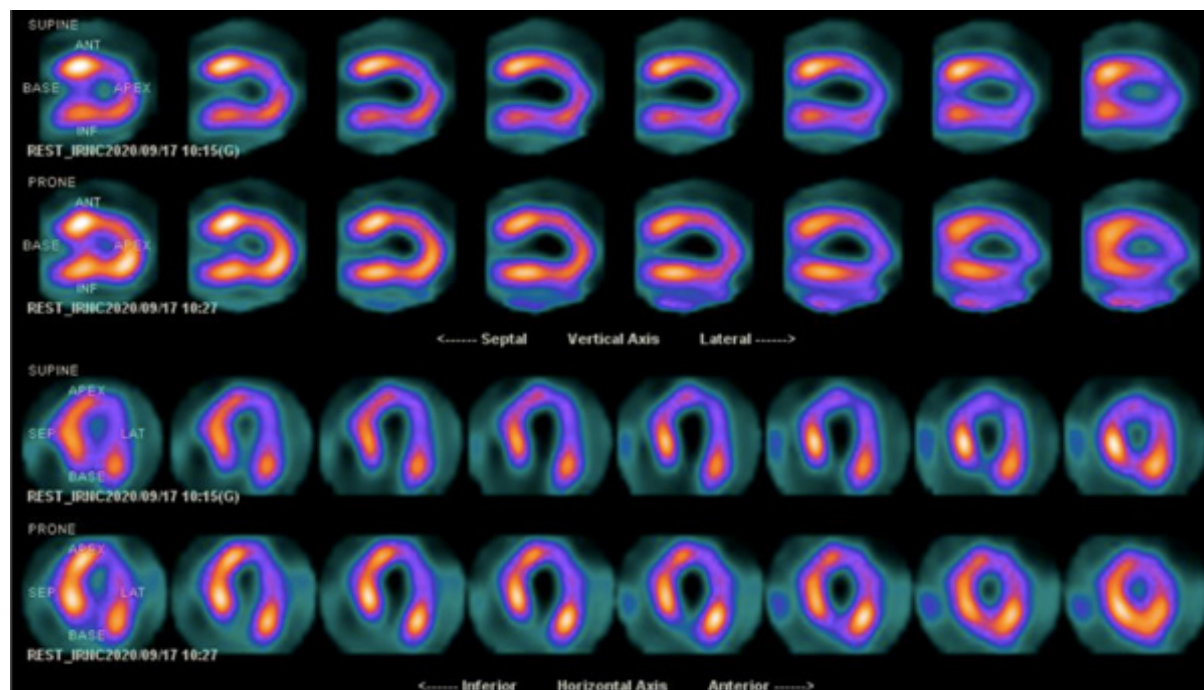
Myocardial scintigraphy with sestamibi-99mTc at rest. It shows an abnormal distribution in myocardial perfusion, with moderate reduction in the apex and mid-apical segments of the lateral wall, with a slight inferolateral extension, affecting 20-25% of the LV area (SRS = 15). The basal regions are preserved.
